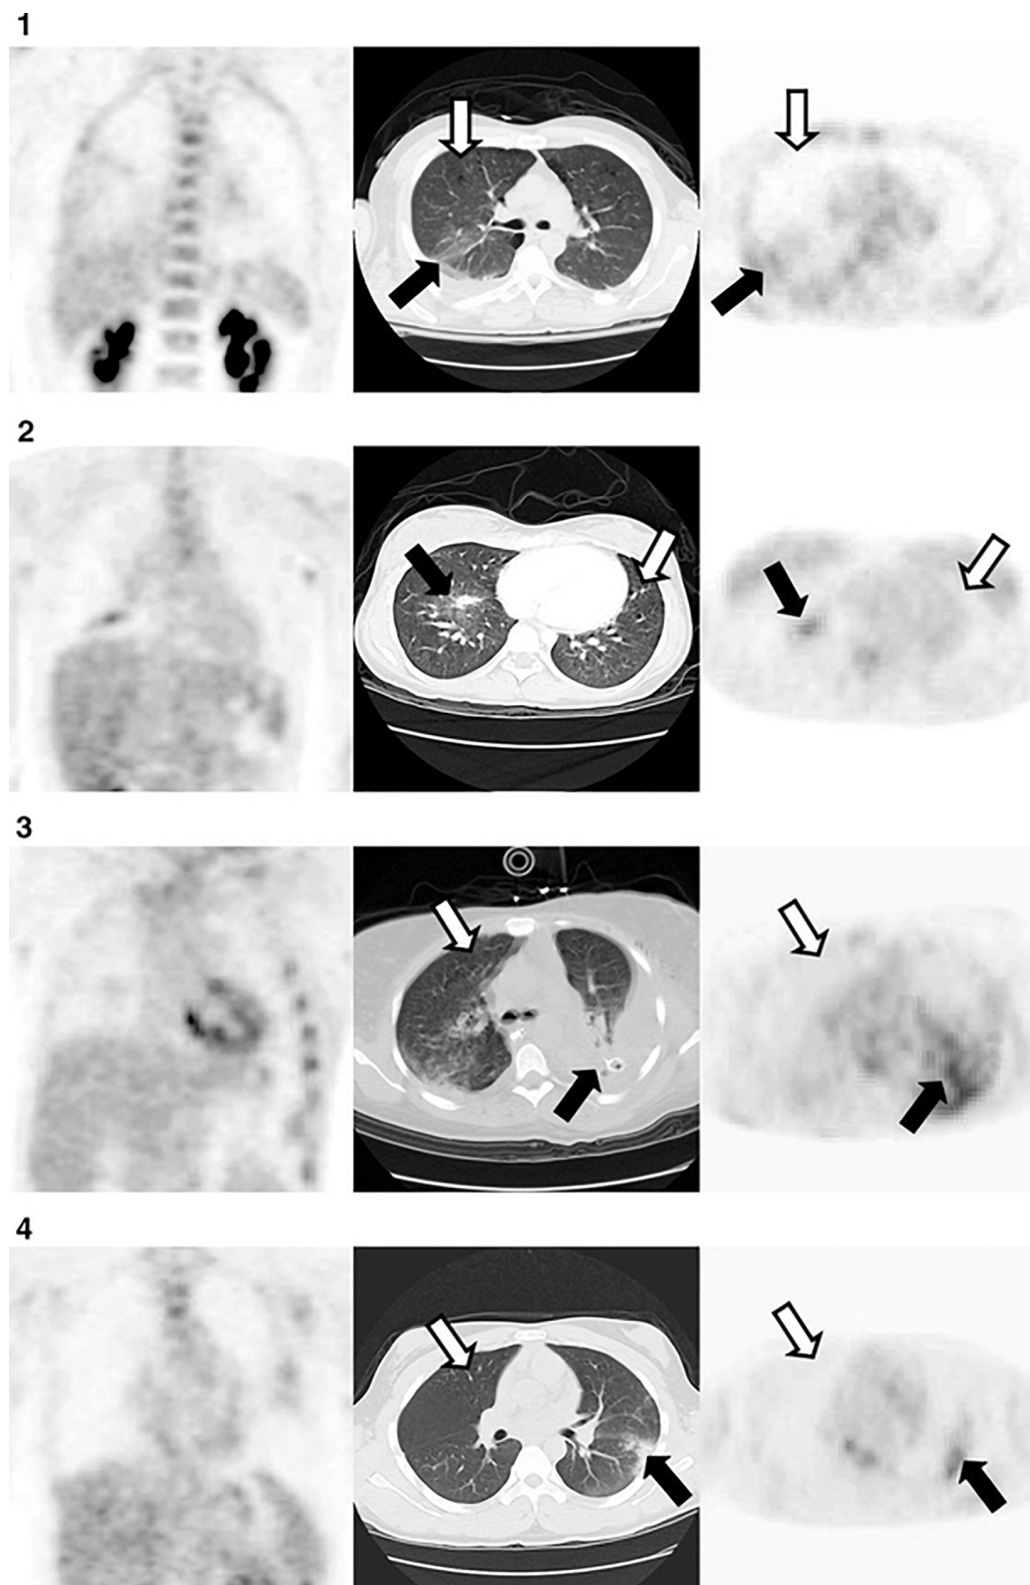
Representative axial computed tomography (CT) in the middle panel, and coronal (left) and axial (right) [^{18}F] fluorodeoxyglucose (^{18}F -FDG) positron emission tomography (PET) at the obtained from 4 patients, 72 hours after diagnosis with acute lung injury. Moderate uptake of FDG was observed in non/poorly aerated regions (black arrows). In contrast, uptake of FDG was low in normally aerated lung (white arrow). Reproduced with permission from Rodrigues et al. (2008).
